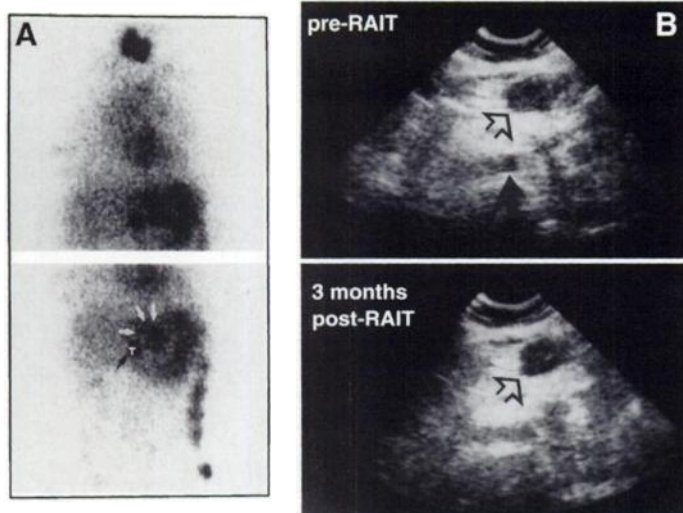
A 54-yr-old patient (Patient 892) with two liver metastases from a colorectal cancer, who underwent two treatments 2 mo apart with 115.8 mCi (7.8 mg) and 159.0 mCi (8.8 mg) ^{131}I -labeled NP-4 IgG. (A) A small liver lesion in the left hepatic lobe (arrow) shows significantly higher antibody uptake than a 3-cm lesion (white arrows) in the immediate neighborhood (close to the small lesion, 218 cGy/mCi; virtual uptake at time zero, 0.95%ID/g). (B) Liver ultrasonography 1 mo after the second treatment (i.e., 3 mo after the first RAIT) shows that the small lesion (solid arrow) has disappeared, whereas the 3-cm liver metastasis (open arrow) in its neighborhood remained essentially unchanged in size.
